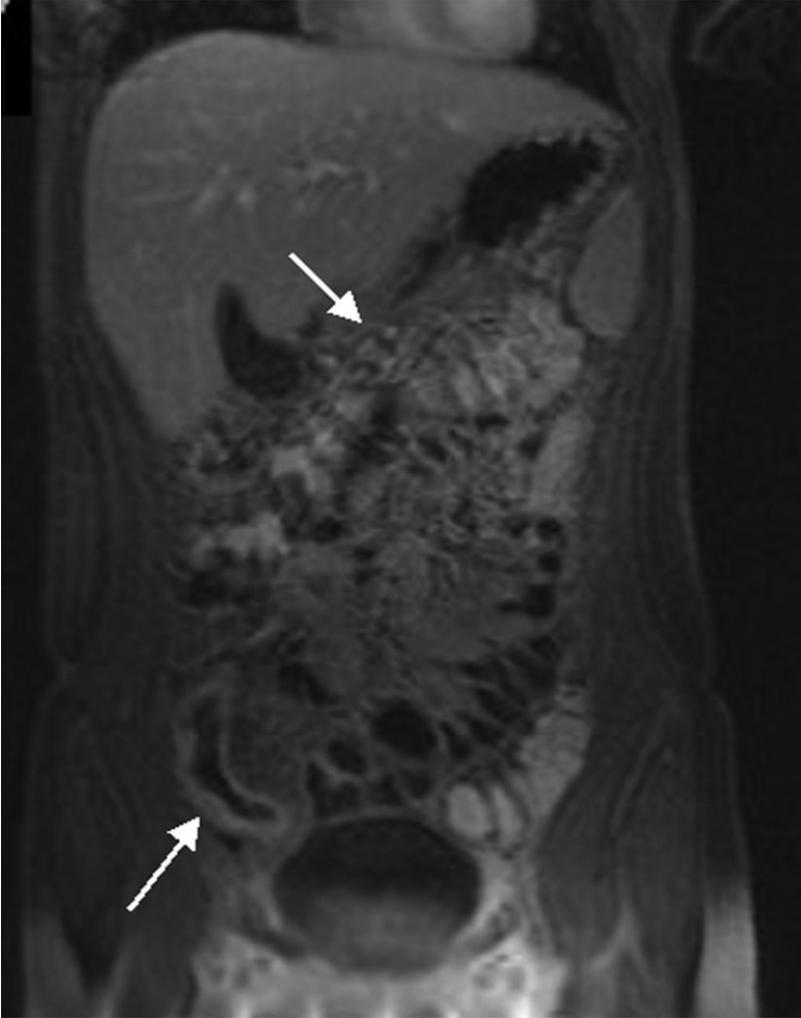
Hydro-MRI without a rectal enema of a 33-year-old female patient with known Crohn's disease. The colonic segments like the transversal colon (arrow) show an insufficient distension. The thickened wall of the terminal ileum shows an increased contrast uptake (arrow). Subsequent endoscopy and biopsy confirmed the presence of an acute inflammation in the terminal ileum.
